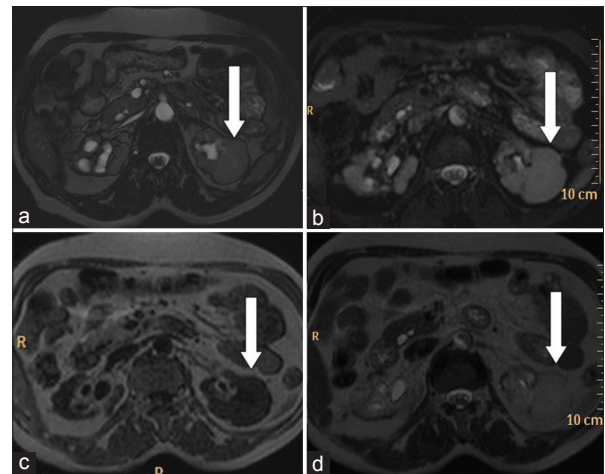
Axial MRI sections balanced fast field echo (a), T2-fat saturation (b) and T1 (c) and T2 (d) show a partly exophytic lesion in the mid pole of left kidney showing the same signal as the rest of the renal parenchyma (white arrows). Both kidneys appear shrunken with nodular surface and mild hydronephrosis
